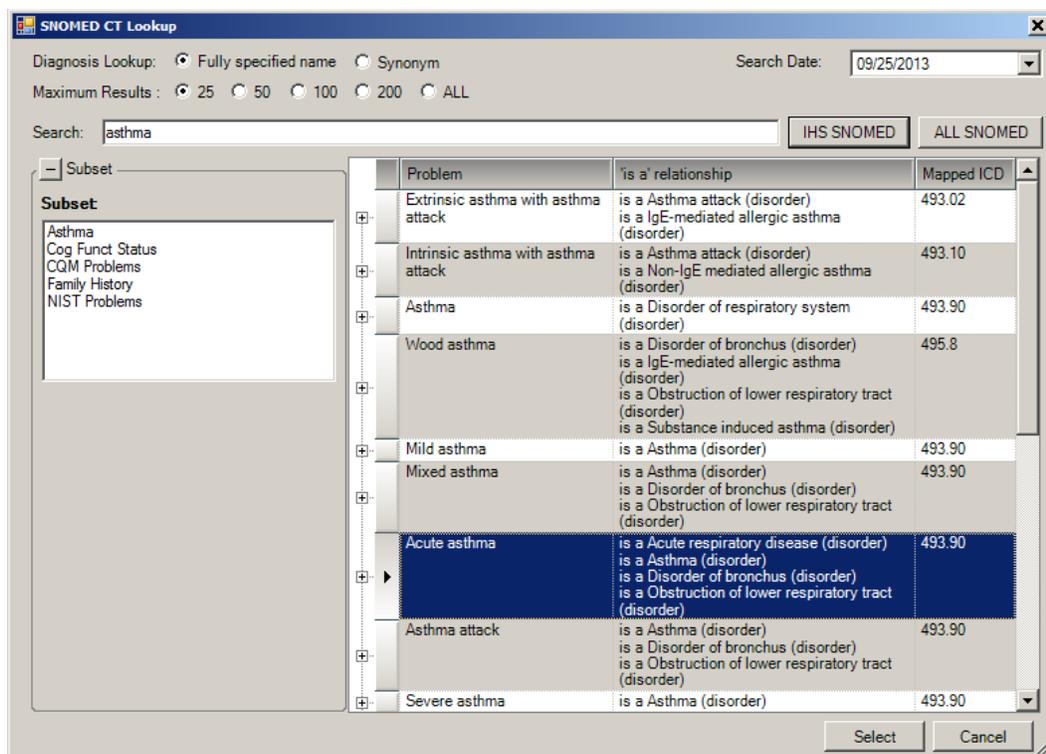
SNOMED CT Lookup dialog
